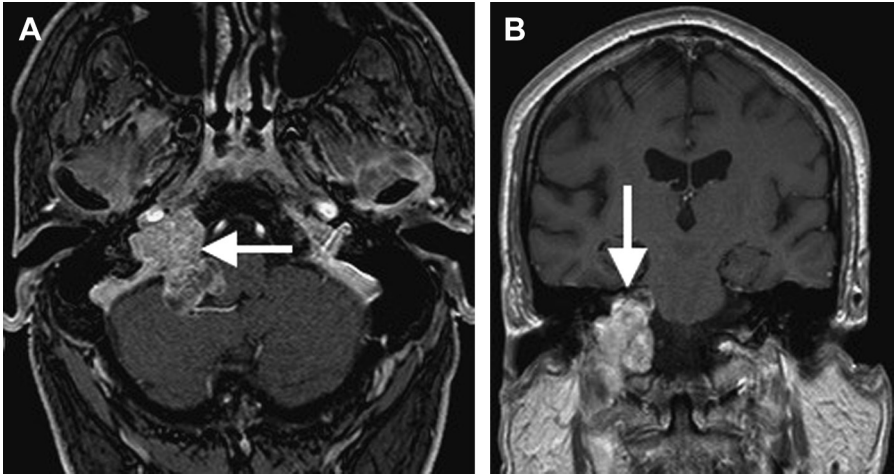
Glomus jugulare as seen on a contrast-enhanced MRI scan. The arrow designates the tumor with a characteristic salt-and-pepper appearance. (A) is an axial cut; (B) is a coronal cut.
